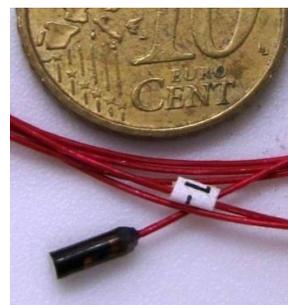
Vermon ultrasonic sensor -Ø2X5.5 mm
